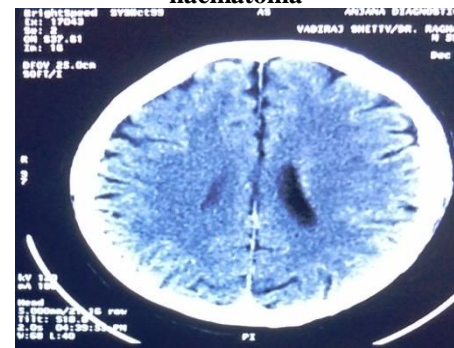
Post-operative CT Scan showing no residual haematoma
